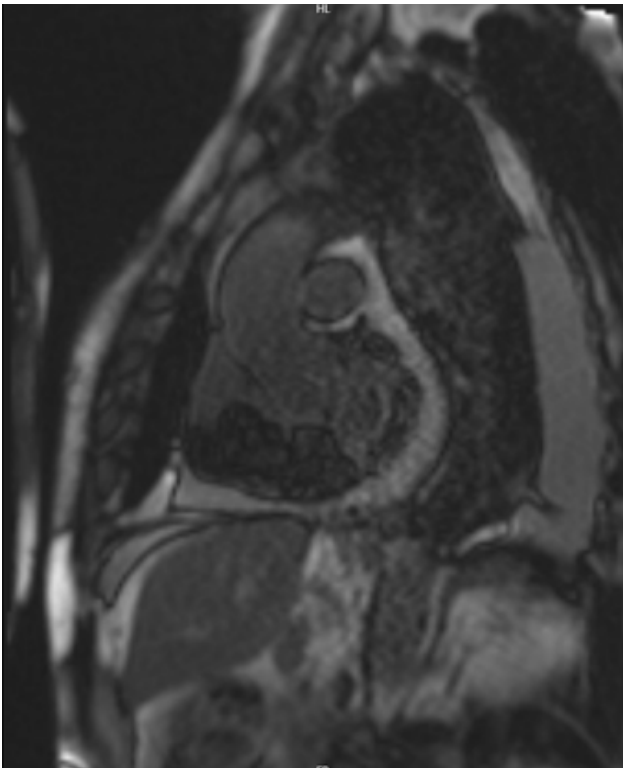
Late gadolinium enhancement of the RV mass on cardiac MRI.
